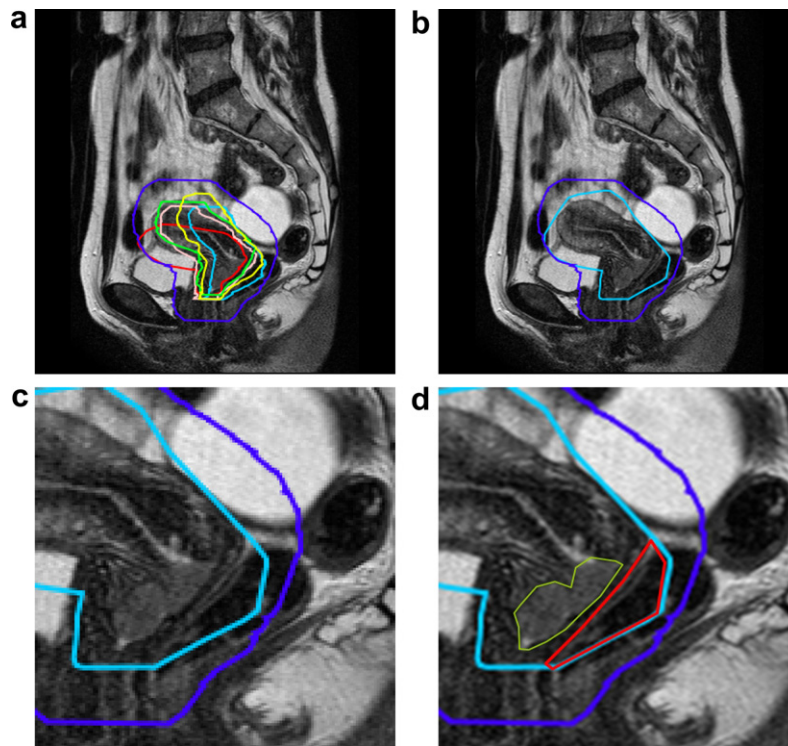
(a) Repeated MRI for carcinoma of the cervix with the five delineated CTVs and the clinically used PTV (dark blue), (b) margins for the adaptive PTV (light blue) based on the series of MRI compared to the clinically used PTV, (c) zoomed MRI show overlap of both the adaptive and the clinical PTV with the rectum, (d) The GTV volume (green) that requires a boost without overdosing the rectum (red).
